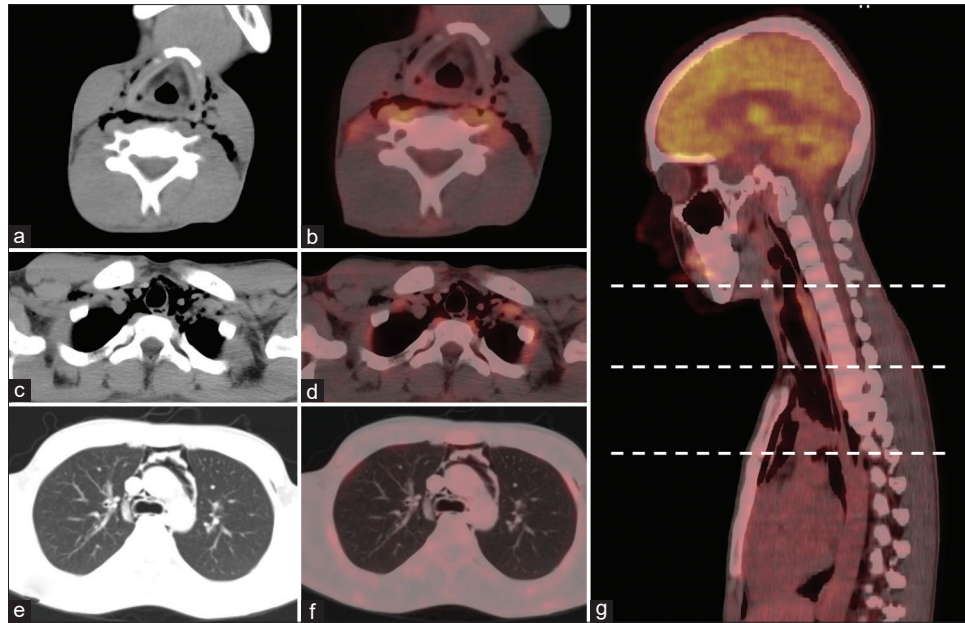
A 15-year-old boy presented with low-grade fever without chills, generalized tonic-clonic seizures, and gradual worsening of memory. The initial workup of the patient was inconclusive. The patient was then referred to the Department of Nuclear Medicine at our institute for a whole-body F-18 fluoro-deoxy-glucose positron emission tomography/computed tomography scan with a provisional diagnosis of paraneoplastic encephalitis. No evidence of any metabolically active lesion was noted anywhere in the body. However, air was incidentally detected in the mediastinum and neck spaces, suggestive of a spontaneous pneumomediastinum and cervical emphysema. (a-f) demonstrates axial sections of computed tomography and fused positron emission tomography/computed tomography at various levels as described in the sagittal section (g). (a and b) shows the presence of air outlining the thyroid cartilage and in the retropharyngeal location. (c and d) demonstrates the presence of air around the great vessels of heart. (e and f) Demonstrates the presence of air in the anterior mediastinum
